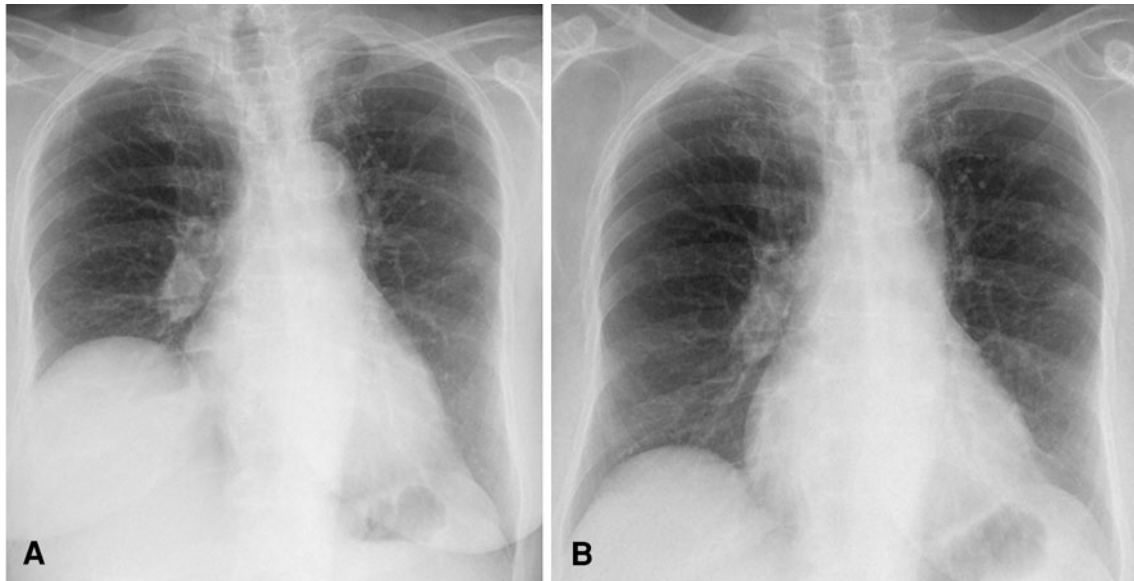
a Chest radiograph shows an elevated right hemidiaphragm. b. Repeat chest radiograph 2 months later showing resolution of the hemidiaphragm elevation
